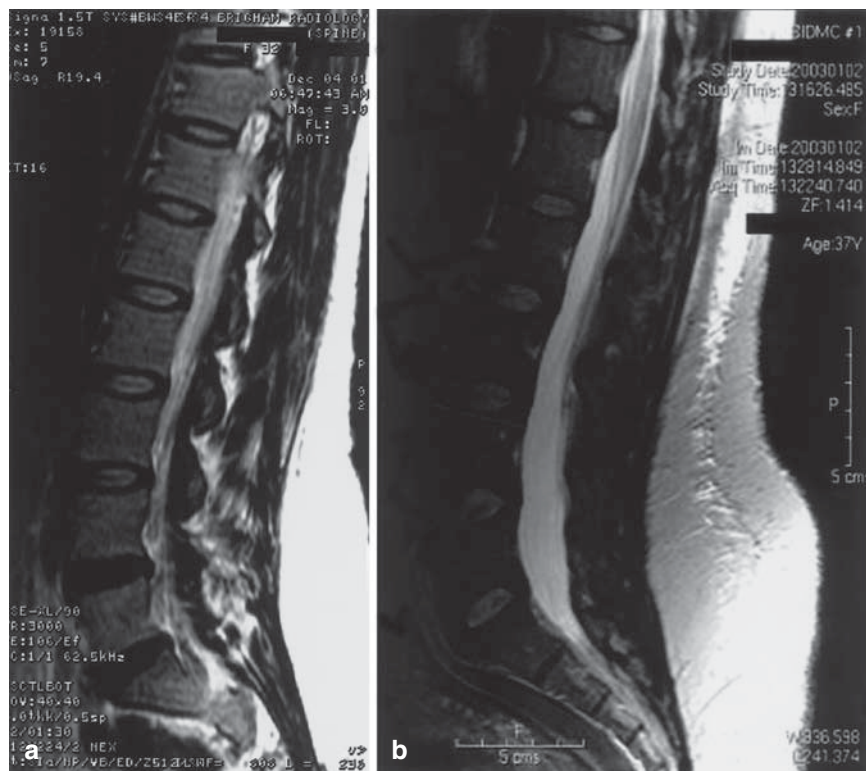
Magnetic resonance images of the lumbosacral spine. a Patient with usual thecal dimensions. b Patient with large thecal dimensions. Compare the intrathecal dimensions of the patient in b (our patient) to the patient in a
